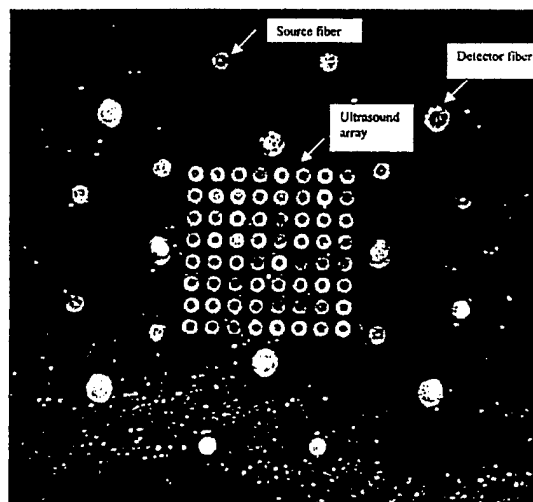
Picture of an experimental probe. An ultrasound array of $8 \times 8 = 64$ transducers occupies the central $3 \text{ cm} \times 3 \text{ cm}$ area, and 12 dual-wavelength source fibers and 8 detector fibers are deployed at the periphery.
